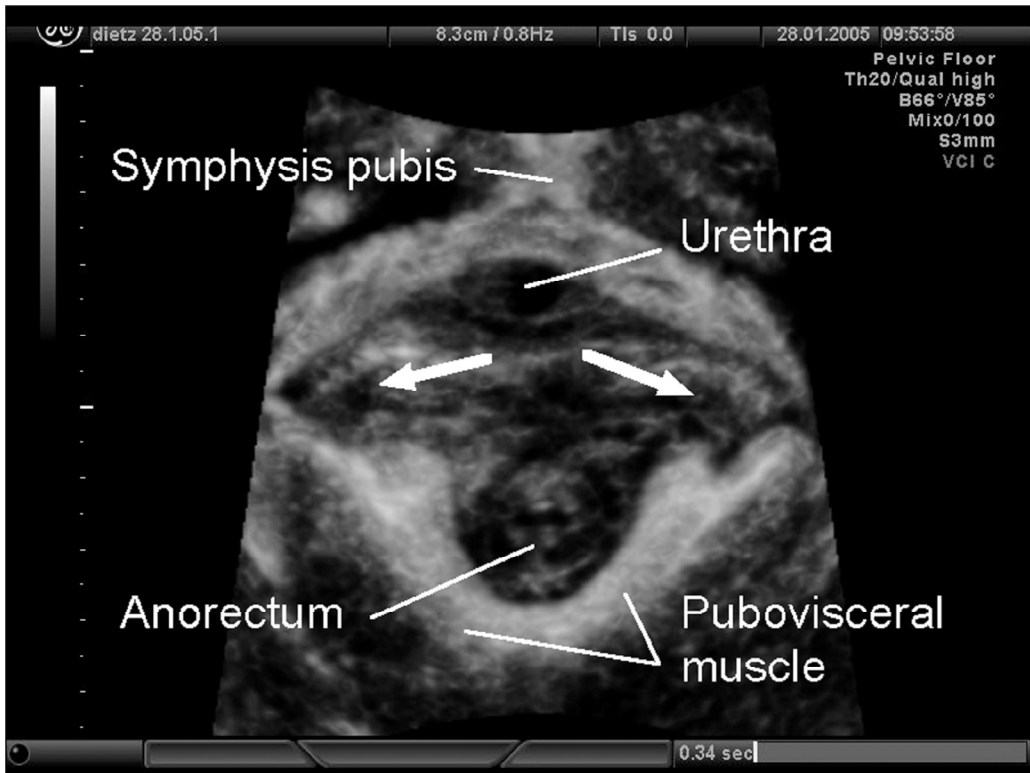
Bilateral avulsion injury of the pubovisceral muscle (see arrows) after rotational forceps delivery. This image was obtained using the latest innovation in 3D ultrasound, Volume Contrast Imaging, which was not yet available for this study. Volume Contrast Imaging allows resolutions close to, if not equivalent to, MRI in the axial plane, while enabling distance, area and volume measurements in any user-defined plane. In combination with 4D imaging, temporal resolutions of several frames a second are possible. Reprinted from Dietz HP and Wilson PD. Pelvic floor dysfunction, best practice and research in obstetrics and gynaecology. In: *Childbirth and Pelvic Floor Trauma* [in press]. (Copyright permission from Elsevier).
